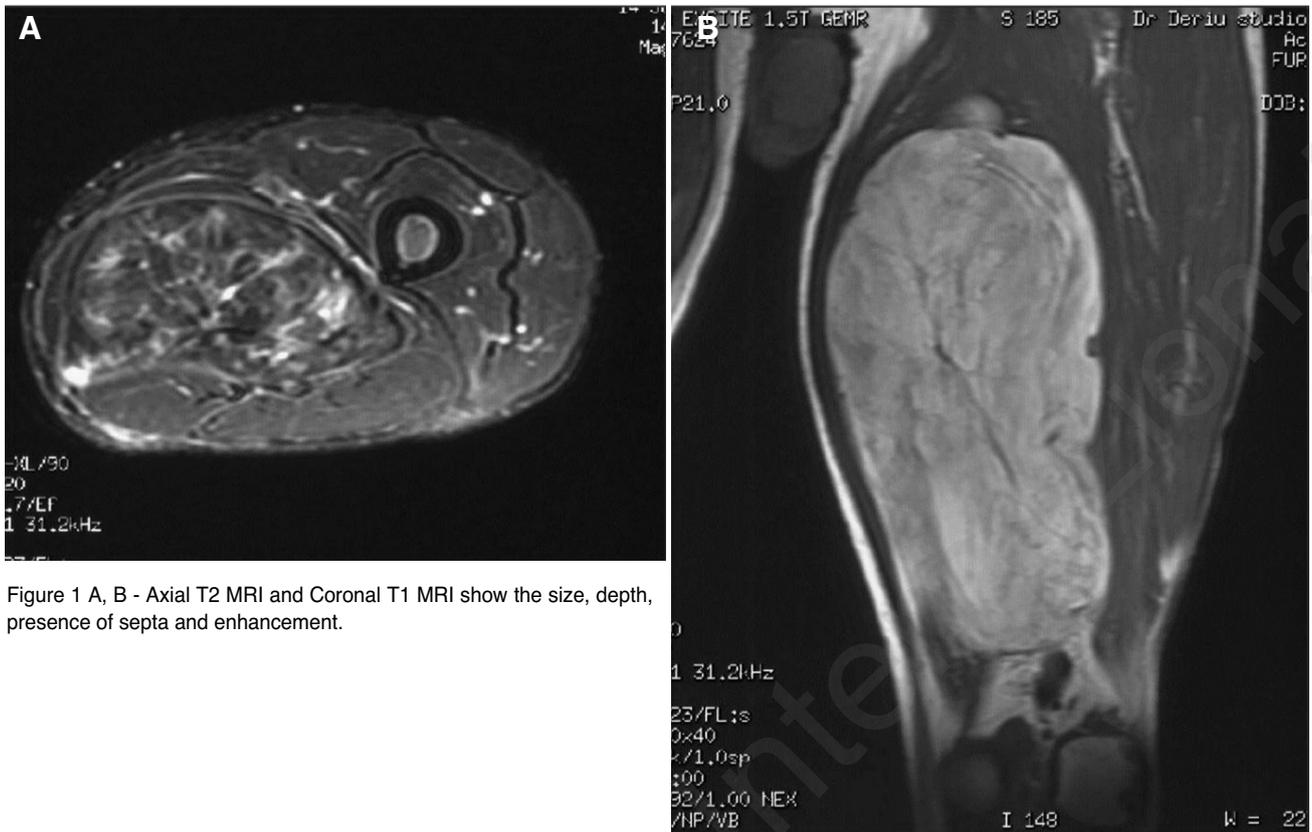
A, B - Axial T2 MRI and Coronal T1 MRI show the size, depth, presence of septa and enhancement.
